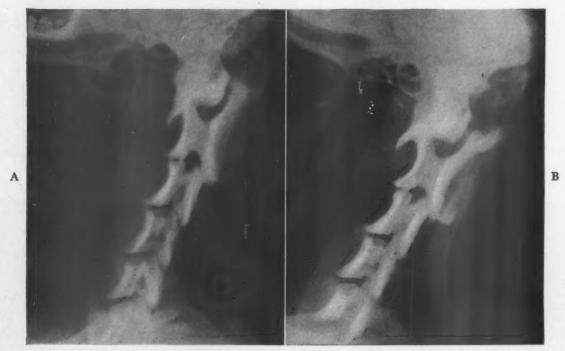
Serial x-ray films of radiopaque clot in carotid artery. A, before treatment. B, after three hours of infusion of fibrinolysin directly into the artery under pressure, showing almost complete lysis of the clot.
